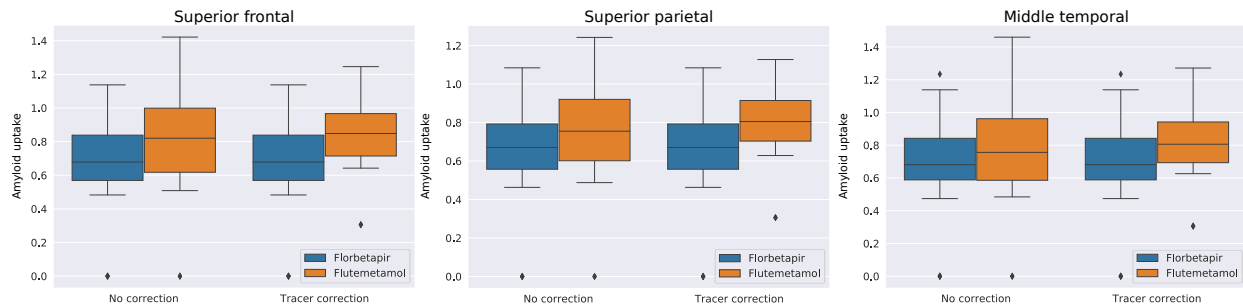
Distribution of the regional amyloid uptake depending on the tracer used during acquisition for the subjects from the GMC cohort. 76 amyloid-PET scans were acquired using florbetapir and 17 using flutemetamol. Tracer correction indicates that the regional amyloid uptake of subjects whose PET scan was acquired using flutemetamol was converted to a florbetapir scale. GMC: Geneva Memory Center; SUVR: Standardized Uptake Value Ratio; PET: Positron Emission Tomography.
